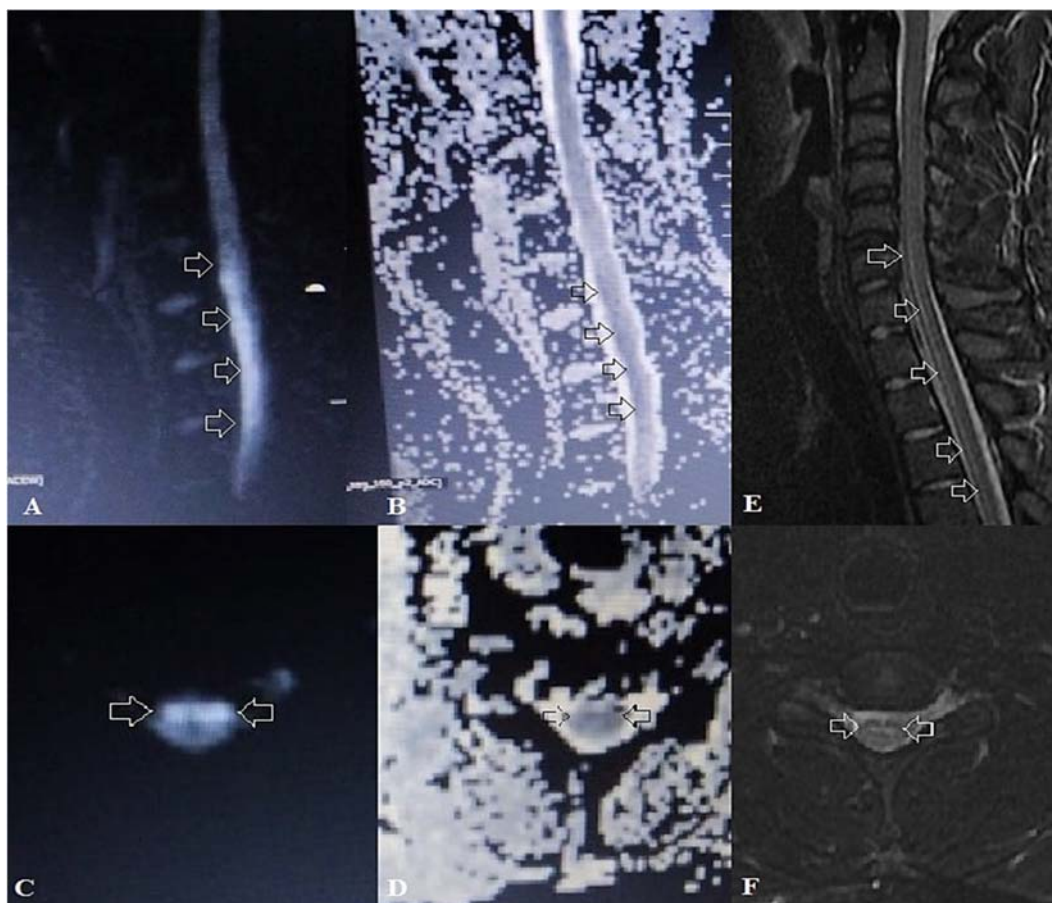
Magnetic resonance imaging (MRI) spine sagittal, diffusion weighted (A), and apparent diffusion coefficient (ADC) (B) sequences show long segment signal change in anterior spinal cord extending from C6 to D4 level with restricted diffusion. Corresponding axial images (C and D) depict diffusion restriction in anterior horns of spinal cord suggesting owl's eye sign. Sagittal and axial short tau inversion recovery (STIR) (E and F) images show subtle hyperintensity.
